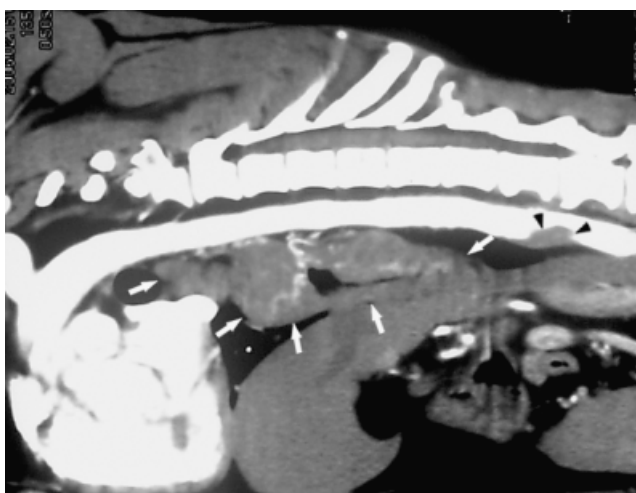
CT-angiogram (WL 32, WW 349) sagittal reconstruction. Note the multilobulated irregular esophageal mass (white arrows) with conspicuous vessels, likely to be enlarged esophageal branches of the bronchoesophageal artery. There is mild aneurysmal dilation of the aorta at the origin of the ventrally located thrombus (black arrow heads).
